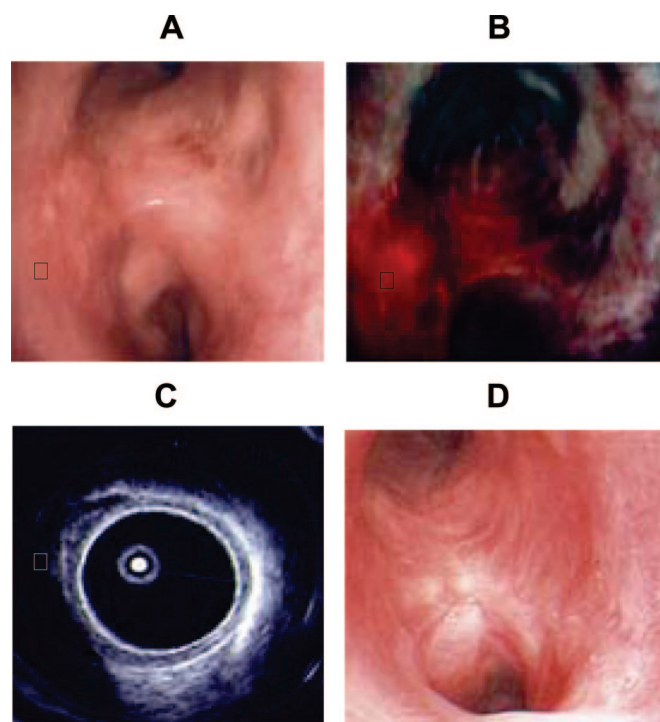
A case of 82-year-old man with primary squamous cell carcinoma. The *star* indicates the tumor lesion. (A) Hypertrophic-type squamous cell carcinoma located at the left upper bronchus. (B) Photodynamic diagnosis using fluorescence bronchoscopy before Laserphyrin PDT. Photodynamic diagnosis image of area of tumor shows red fluorescence. (C) Endobronchial ultrasound imaging shows a small tumor before Laserphyrin PDT. The tumor appears as an isoechoic area and was diagnosed as intracartilaginous. (D) Three months after Laserphyrin PDT. Complete response was obtained.
